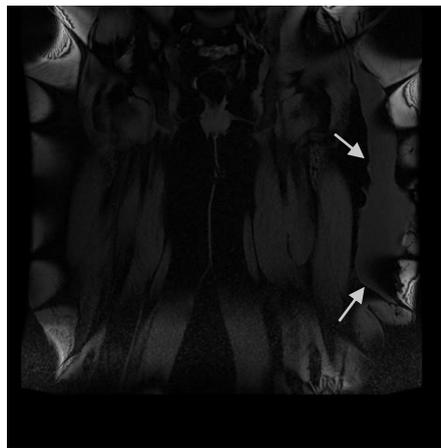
T1 weighted images in MRI shows a subcutaneous elongated fluid collection (arrows) at the upper lateral left thigh region, it measures 32.5cm x10cm x6.2cm in its maximum dimensions. It shows low signal in T1WI.
